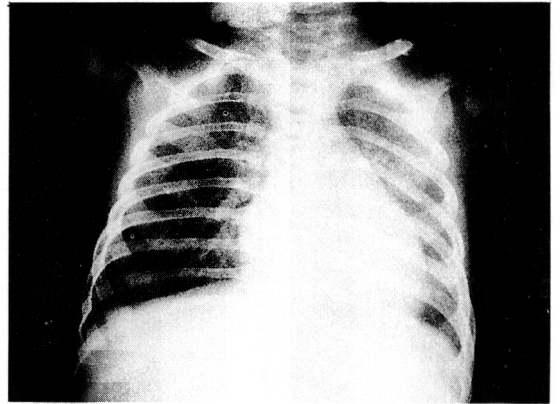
A chest x-ray taken, after 7 days of treatment with recombinant human interferon-gamma, shows much improvement of haziness on both lung fields.
